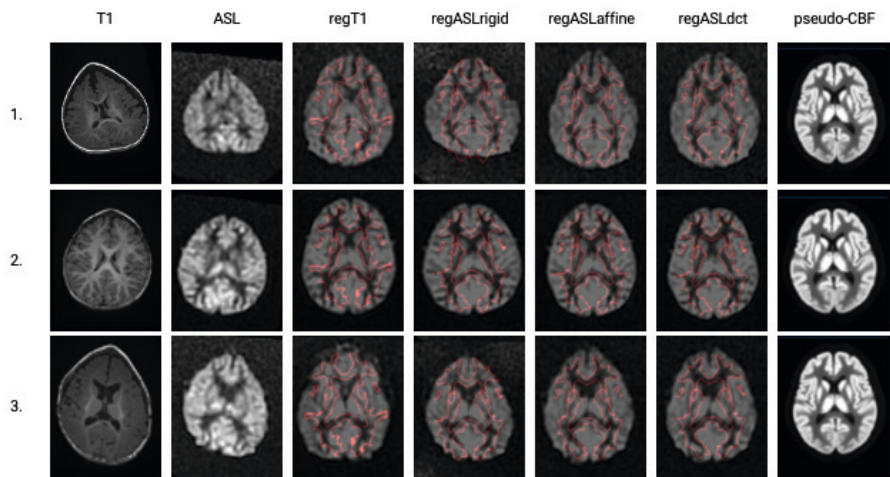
A single axial slice is shown (columns left to right) for the T1-weighted image and the ASL image in their native space before registration and for the results of the four registration methods in the standard space: regT1, regASLrigid, regASLaffine, and regASLdct of three trigonocephaly subjects (rows). In the standard space, a CBF image is shown with borders of the WM from the template (with a threshold at 50%) shown in red. Finally, the pseudo-CBF images of the three trigonocephaly patients are shown.
